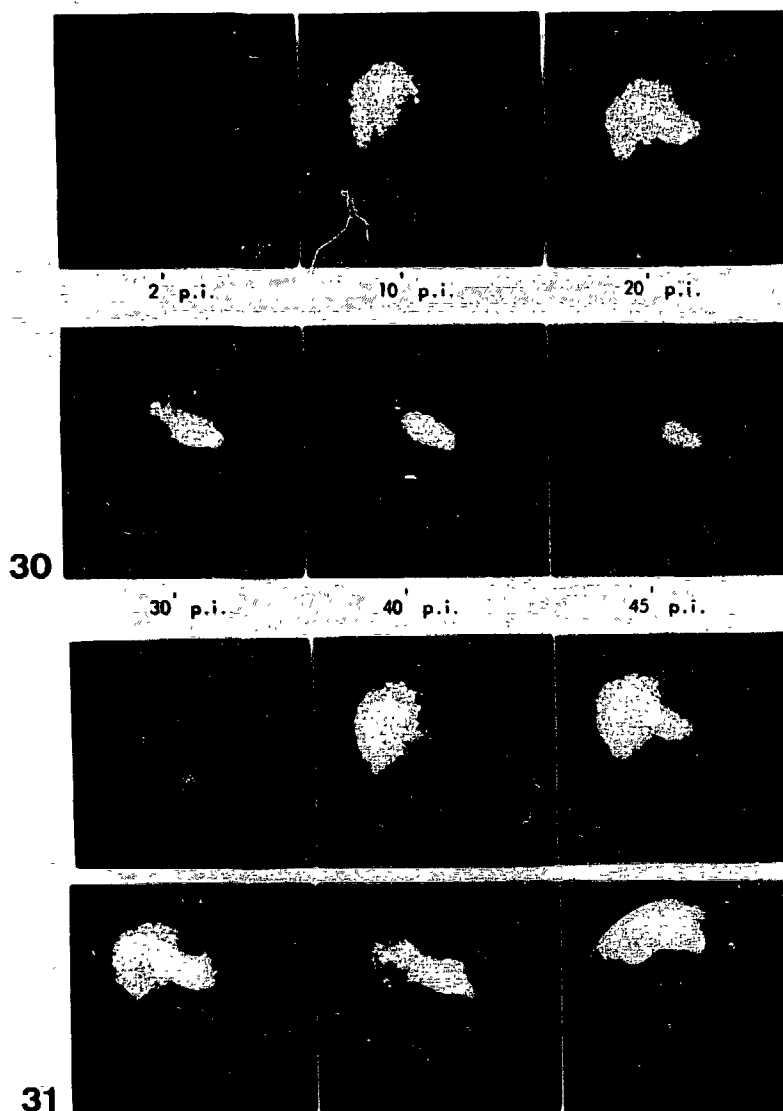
30 Serial scintigram of a non-fasted patient without liver or biliary tract disease.
